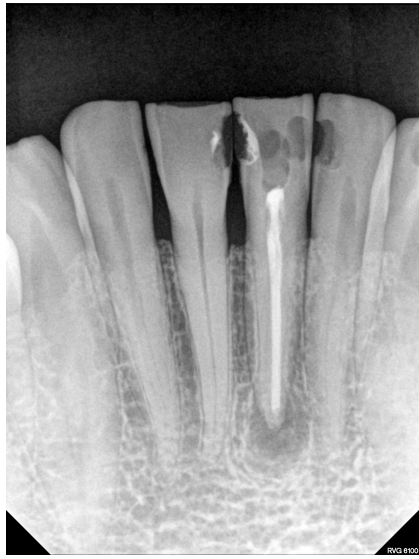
Figure #6: A clinical case where CBCT imaging (bottom) confirmed a missed lingual canal as presumptive etiology for persistent apical periodontitis with preoperative (upper left) and immediate postoperative (upper right) periapical radiographs.
